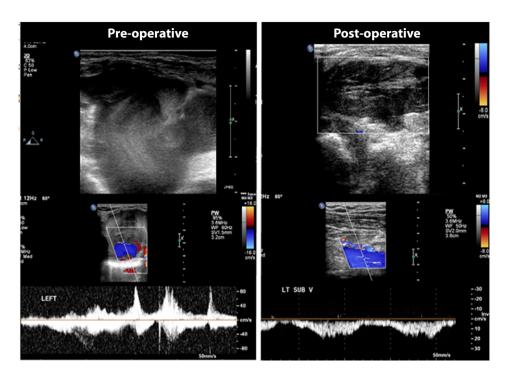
Duplex scanning of the left side of the root of neck. Pre-operative: 2D image showing a huge venous sac with whirling of blood. Respiro-phasic Doppler waveform accentuated by Valsalva maneuver confirms its venous communication; post-operative: color image showing totally thrombosed venous aneurysm with absent flow. Doppler waveform at the left subclavian vein shows normal venous flow.
